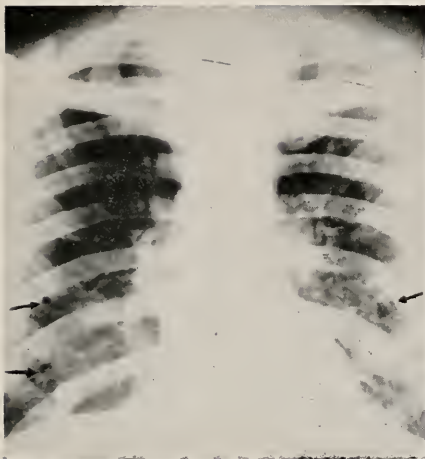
Case I—X-Ray: Coarctation of the Aorta
